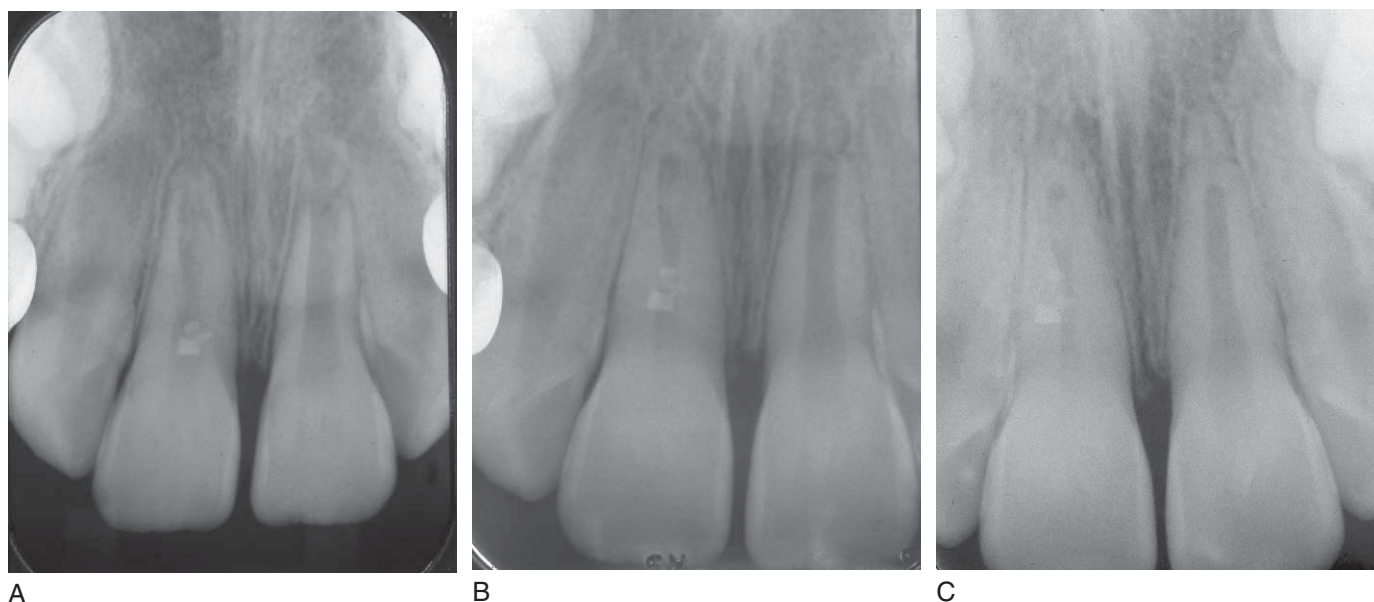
The increased vascularity of an immature root may help the tooth stay vital subsequent to an intraalveolar root fracture. This is evident radiographically in A-C, each exposed 4 months apart, as the root of the tooth has continued its normal maturation and development.
